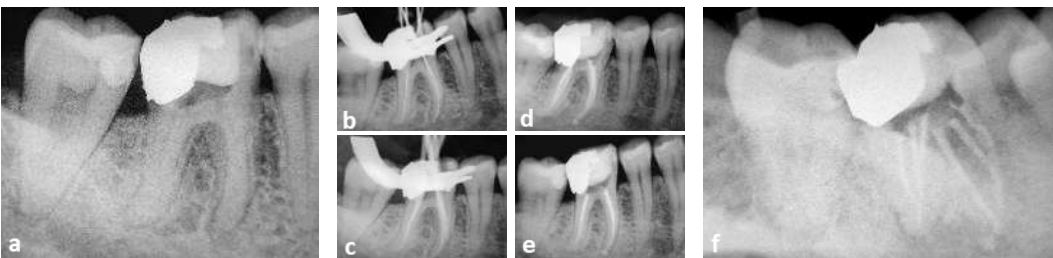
Periapical Radiographs: a) Preoperative, b) Working length determination, c) Master cone fitting, d) Postoperative straight angulation, e) Postoperative mesial angulation, f) Postoperative distal angulation
